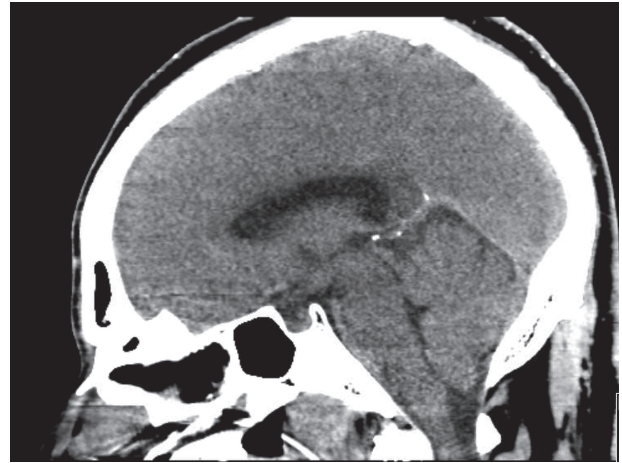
CT head (non-contrast). Axial image: There is cerebral sulcal effacement of both hemispheres at the convexity in keeping with cerebral oedema.
